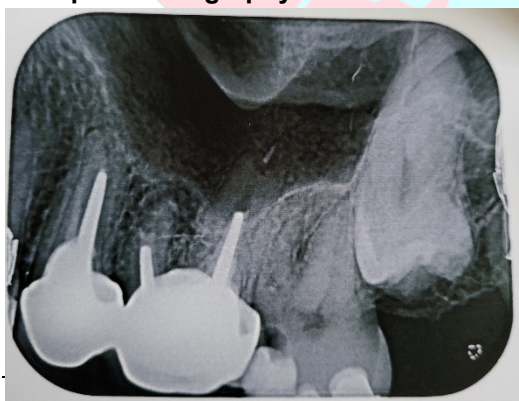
Periapical radiography
